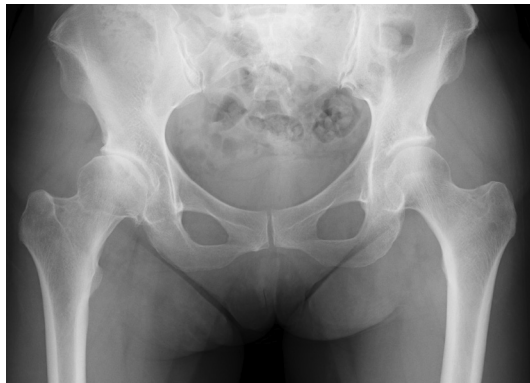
Hip X-ray of a male adult in his late 50s. This male adult with thalidomide embryopathy was affected by hearing impairment but no limb malformations. Both hips show acetabular dysplasia and the joint space in the right is narrow.
